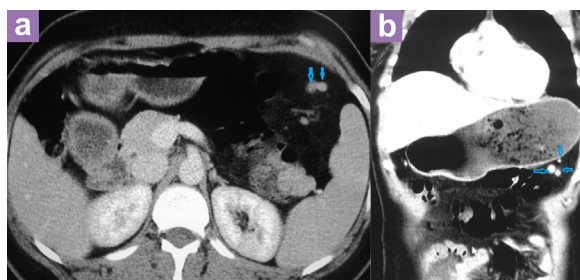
Contrast enhanced computed tomography image (a) axial section showing two small accessory spleens (blue arrows) anterior to the main spleen. (b) Coronal section of the same patient showing three small accessory spleens (blue arrows) in a more anterior plane than the main spleen, located inferior to the greater curvature of the stomach.
